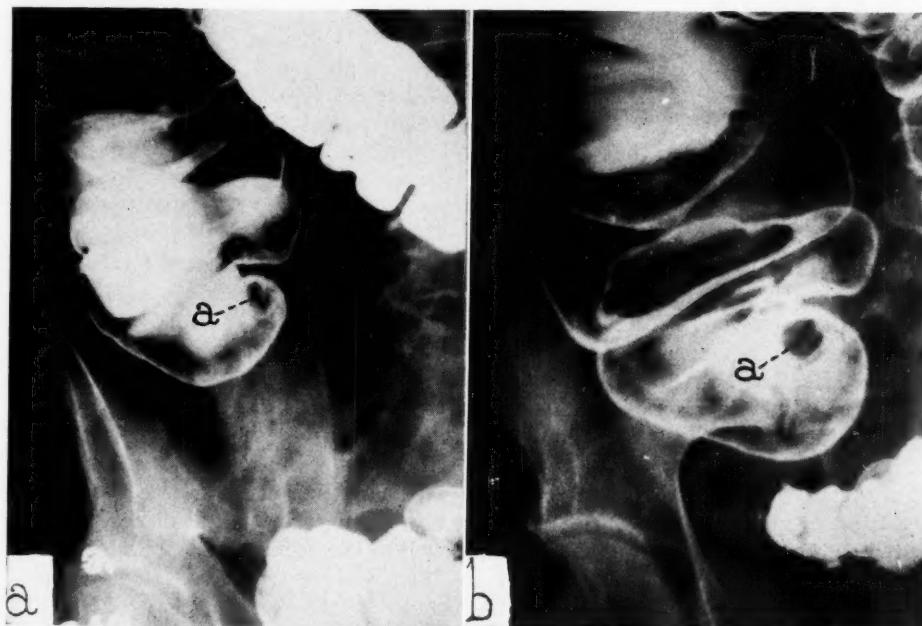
Roentgenograms of the colon made with the double contrast method in Case 3. *A*, Roentgenogram made while the patient was supine. *B*, Roentgenogram made while the patient was prone. The well-circumscribed circular defect at *a* represents the invaginated appendiceal stump.
